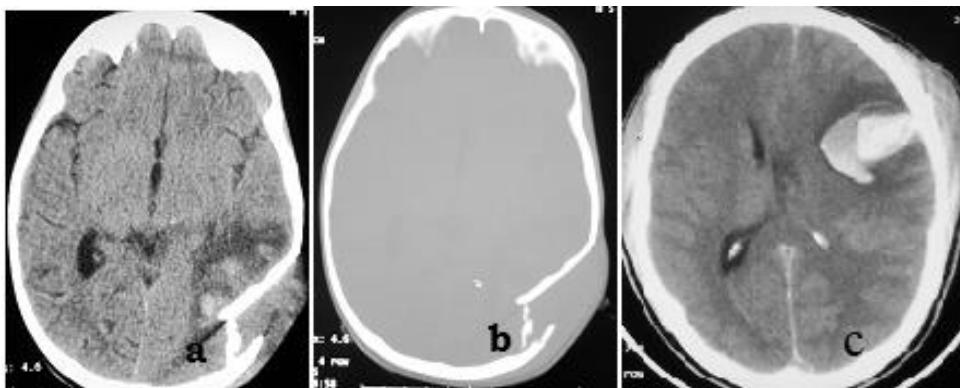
CT scans showing brain injuries. (a) Skull fractures and brain contusion with adjacent oedema. (b) Bone window of the CT in (a) clearly showing the fracture. (c) Brain contusion with brain haematoma. Note also the adjacent scalp swelling.
